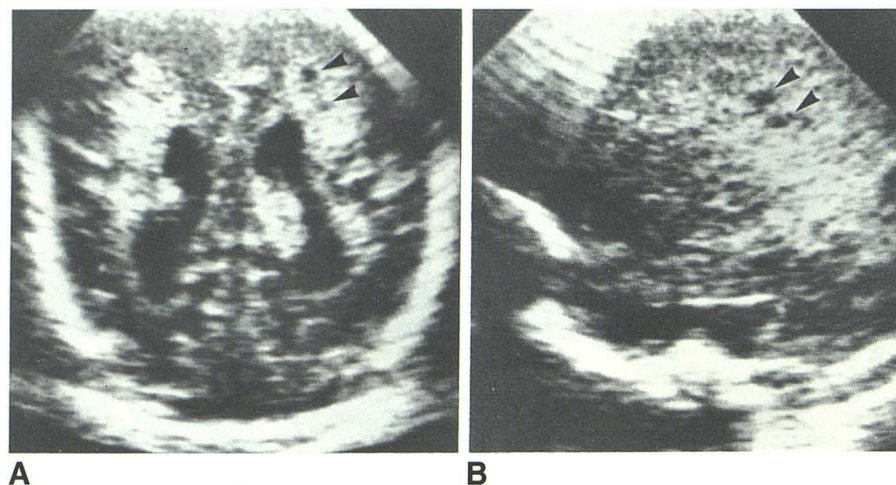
Case 3. Nonhemorrhagic PVL. Initial sonograms showed left germinal matrix hemorrhage at 2 days and ventriculomegaly and increased periventricular echogenicity at 8 days. Coronal (A) and left parasagittal (B) sonograms on day 13. Small cysts (arrowheads) had developed within periventricular echogenic areas. Lateral borders of echogenic areas were irregular but well defined.
